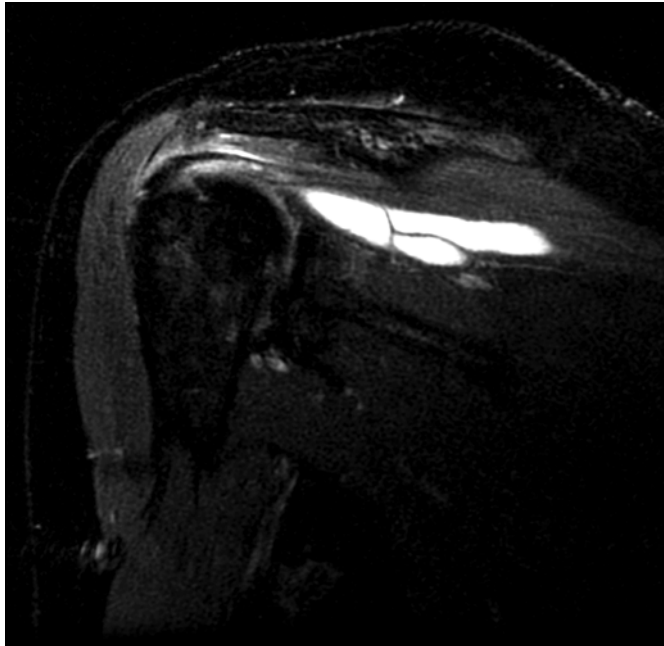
29-year-old man with shoulder pain. Coronal oblique T2-weighted image shows intraspinatus cyst with intact infraspinatus tendon. Patient had supraspinatus tendon tear (not shown). Partial-thickness articular surface tear of supraspinatus and intact infraspinatus were confirmed at arthroscopy.
